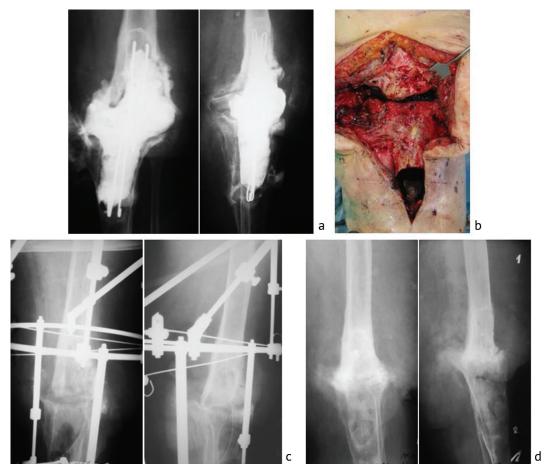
A case of successful knee joint ankylosis in patient B., 71 years old, with type II defect according to AORI:  $\boldsymbol{a}$  fistulograms of the knee joint;  $\boldsymbol{b}$  co-aptation of the bones after resection (type II defect according to AORI);  $\boldsymbol{c}$  radiographs of the knee joint after arthrodesis;  $\boldsymbol{d}$  result of treatment (bone ankylosis) after a 4-month fixation
